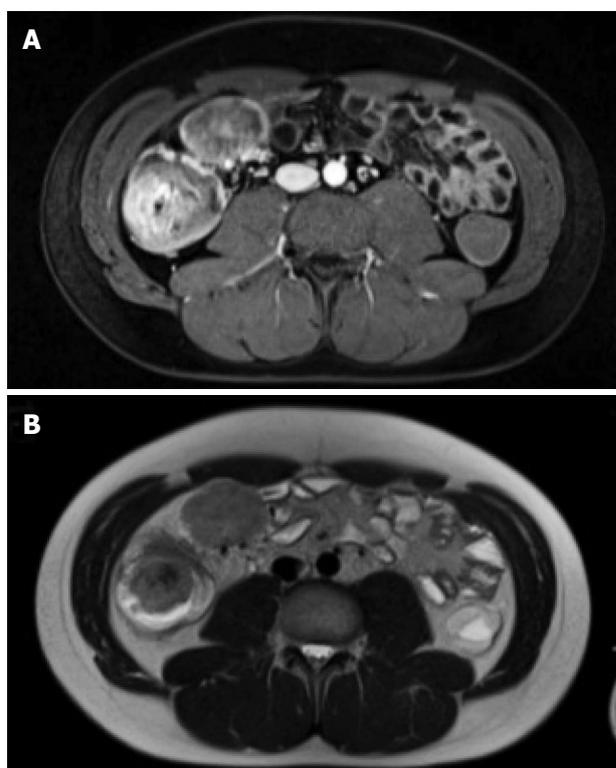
Magnetic resonance imaging of cecal perivascular epithelioid cell tumor and mesenteric lymph node metastasis. A: T2-weighted image; B: T1-weighted image after iv administration of contrast medium.
